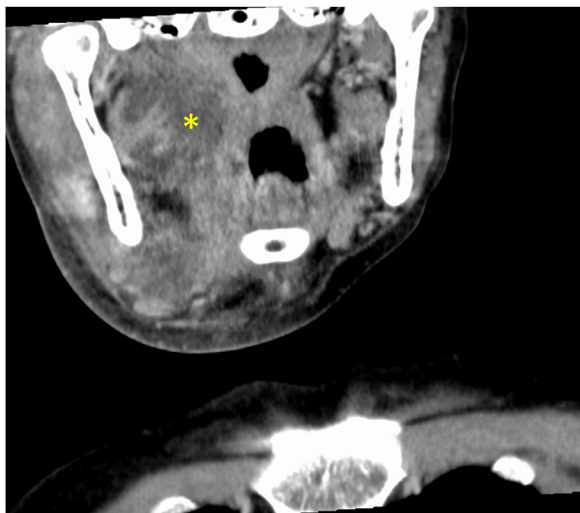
Contrast-enhanced computed tomography showing the abscesses extending from the right parapharyngeal to the submandibular space (asterisk).
